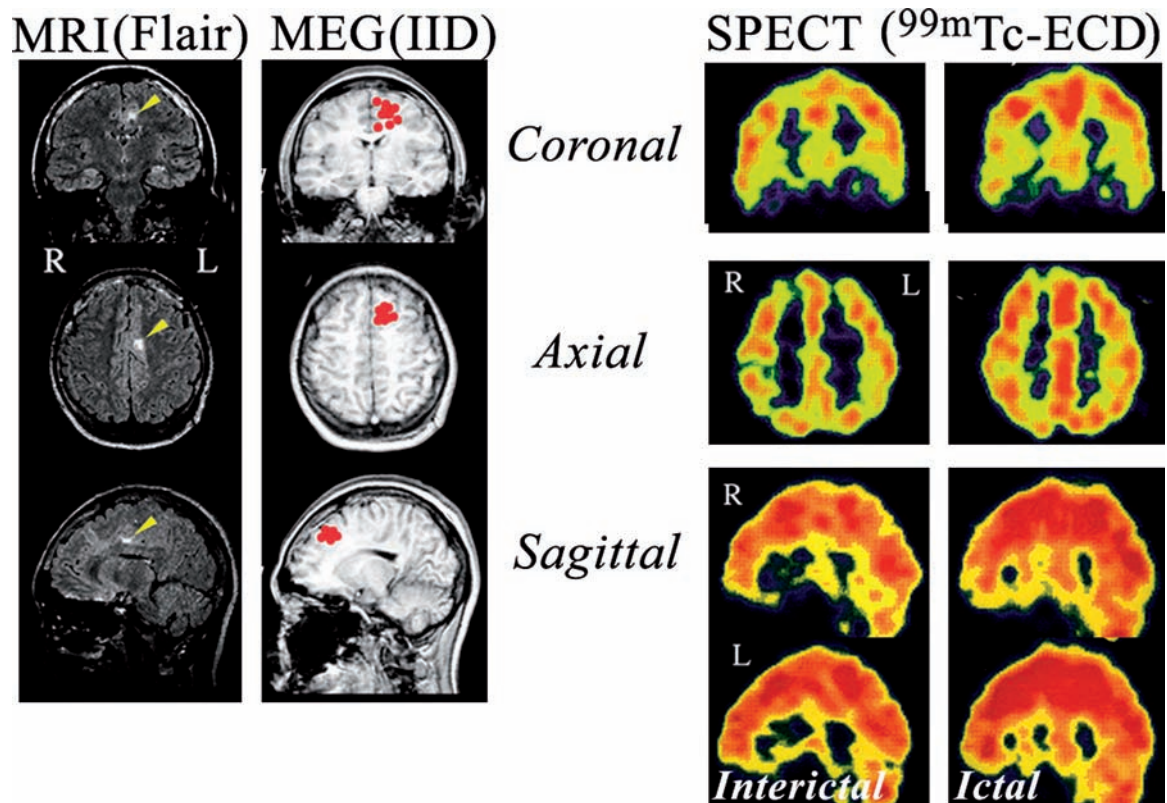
Magnetic resonance imaging (MRI), equivalent current dipoles (ECD), and single-photon emission computed tomography (SPECT) of a patient with an activated MCC during seizures. Far left: On the MRI fluid attenuated inversion recovery (FLAIR), a high-signal, circumscribed lesion is found in the left medial frontal lobe. Left: The ECD derived from interictal magnetoencephalography (MEG) spikes (red dots) cluster in the left frontomedial lobe, possibly near the supplementary motor area. Right: Interictal SPECT shows no abnormal perfusion in the medial cortex of frontal lobe bilaterally. A greater increase on the left side can be observed during the seizure. Used with generous permission from H. Shiraishi (Shiraishi *et al.*, 2001).
